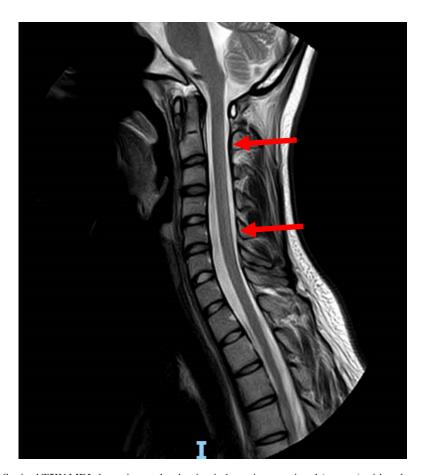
B. Sagittal T2W MRI shows interval reduction in hyperintense signal (arrows) with reduced swelling and thickness, although faint hyperintensity is still seen in the previous longitudinal extent of involvement.
